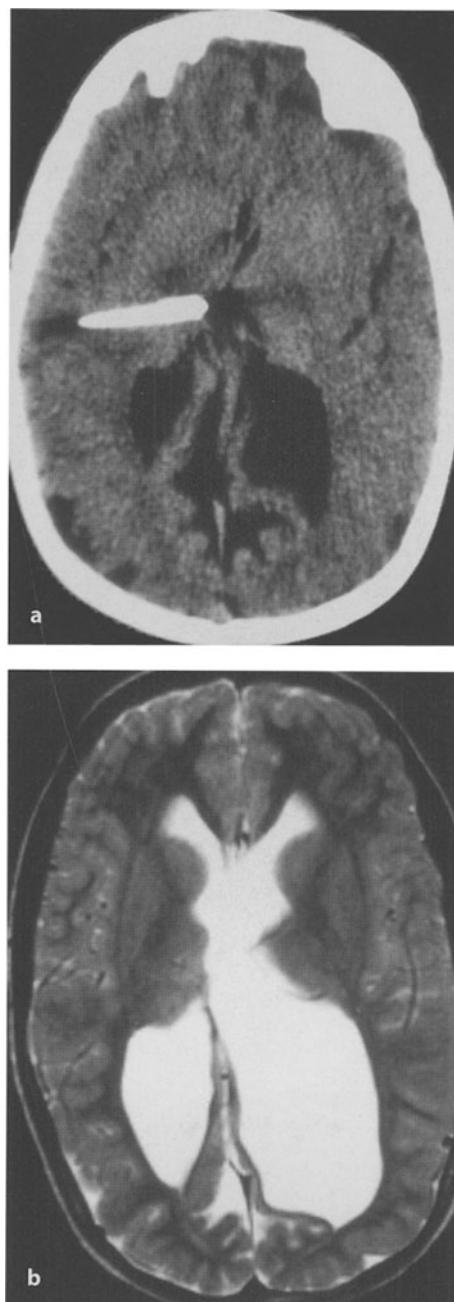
Girl affected by myelomeningocele and hydrocephalus, shunted at birth in a developing country. a CT scan at the age of 9 years: the proximal catheter is in the right thalamus, ventricles are small. b Follow-up MRI at the age of 11 years: the shunt is blocked, the ventricles are dilated, the patient has no signs or symptoms of intracranial hypertension. The parents refused any treatment. Two years later the patient was readmitted with severe epilepsy that resolved following shunt revision
